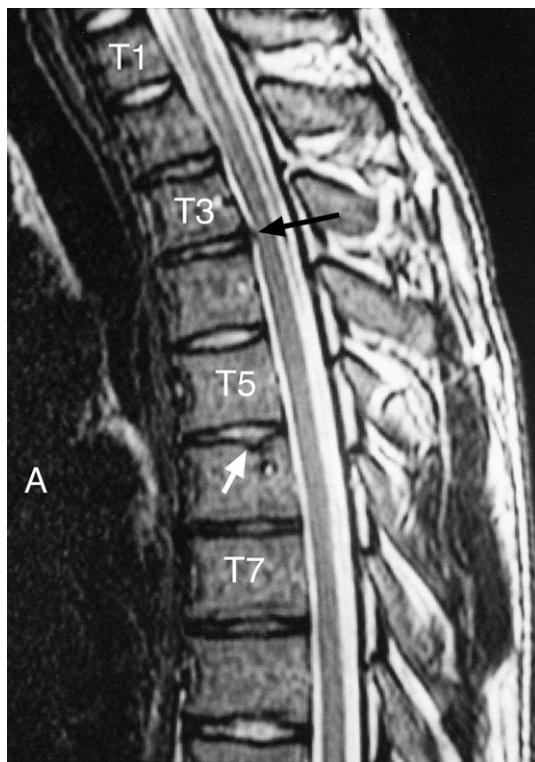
Thoracic spine MRI sagittal T2-weighted image. Note (i) there appears to be a small posterior disc bulge at the T3–4 level pressing upon the pain sensitive anterior part of the dural tube/thecal sac (black arrow), (ii) there is moderate desiccation of the T2–3, T3–4, T6–7 and T7–8 thoracic discs, and (iii) there is a Schmorl's node in the superior endplate of the T6 vertebral body (white arrow) where disc material has herniated through a fracture in the endplate.
